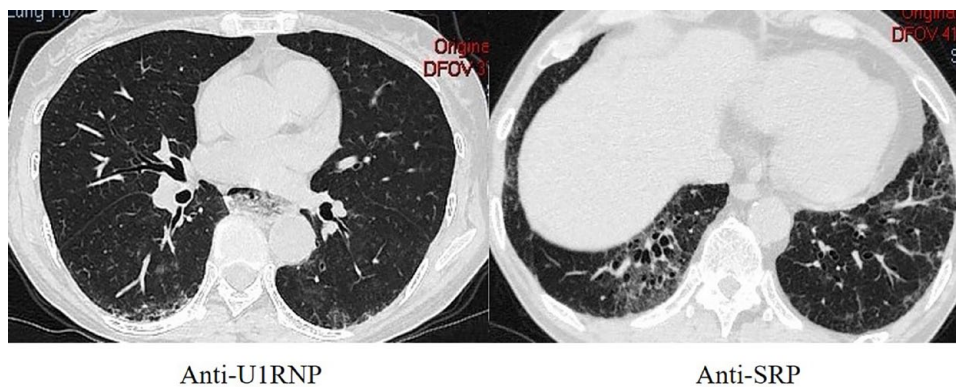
High-resolution CT scan from myositis patients with anti-U1RNP and anti-SRP. SRP, signal recognition particle; U1RNP, U1 ribonucleoprotein.
